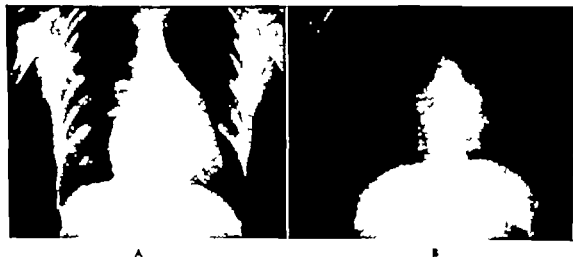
Red clot. In the overall size of the heart following relief of the mitral obstruction. A. Preoperative posteroanterior roentgenogram, B. postoperative comparable roentgenogram six months followup.
